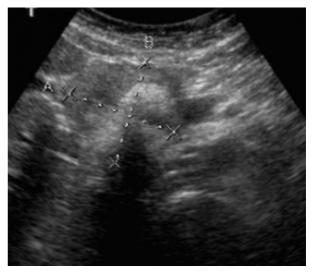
Abdominal ultrasonography reveals a solid mass in the head of the pancreas, with an eccentric hyperechoic component consistent with calcification.
